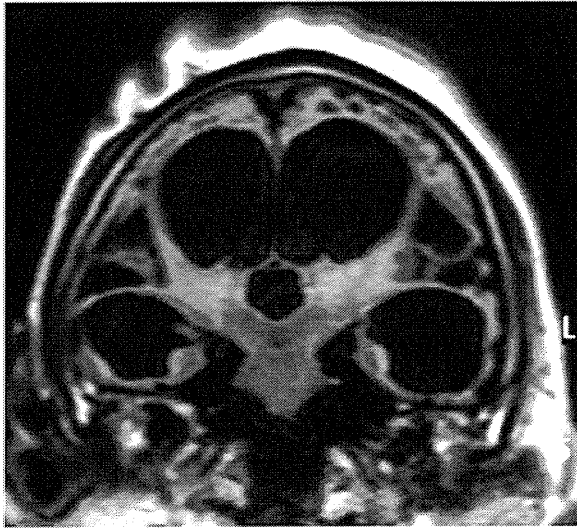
MRI at 30 years of age. Coronal FLAIR image shows cortical thinning and ulegyria.
